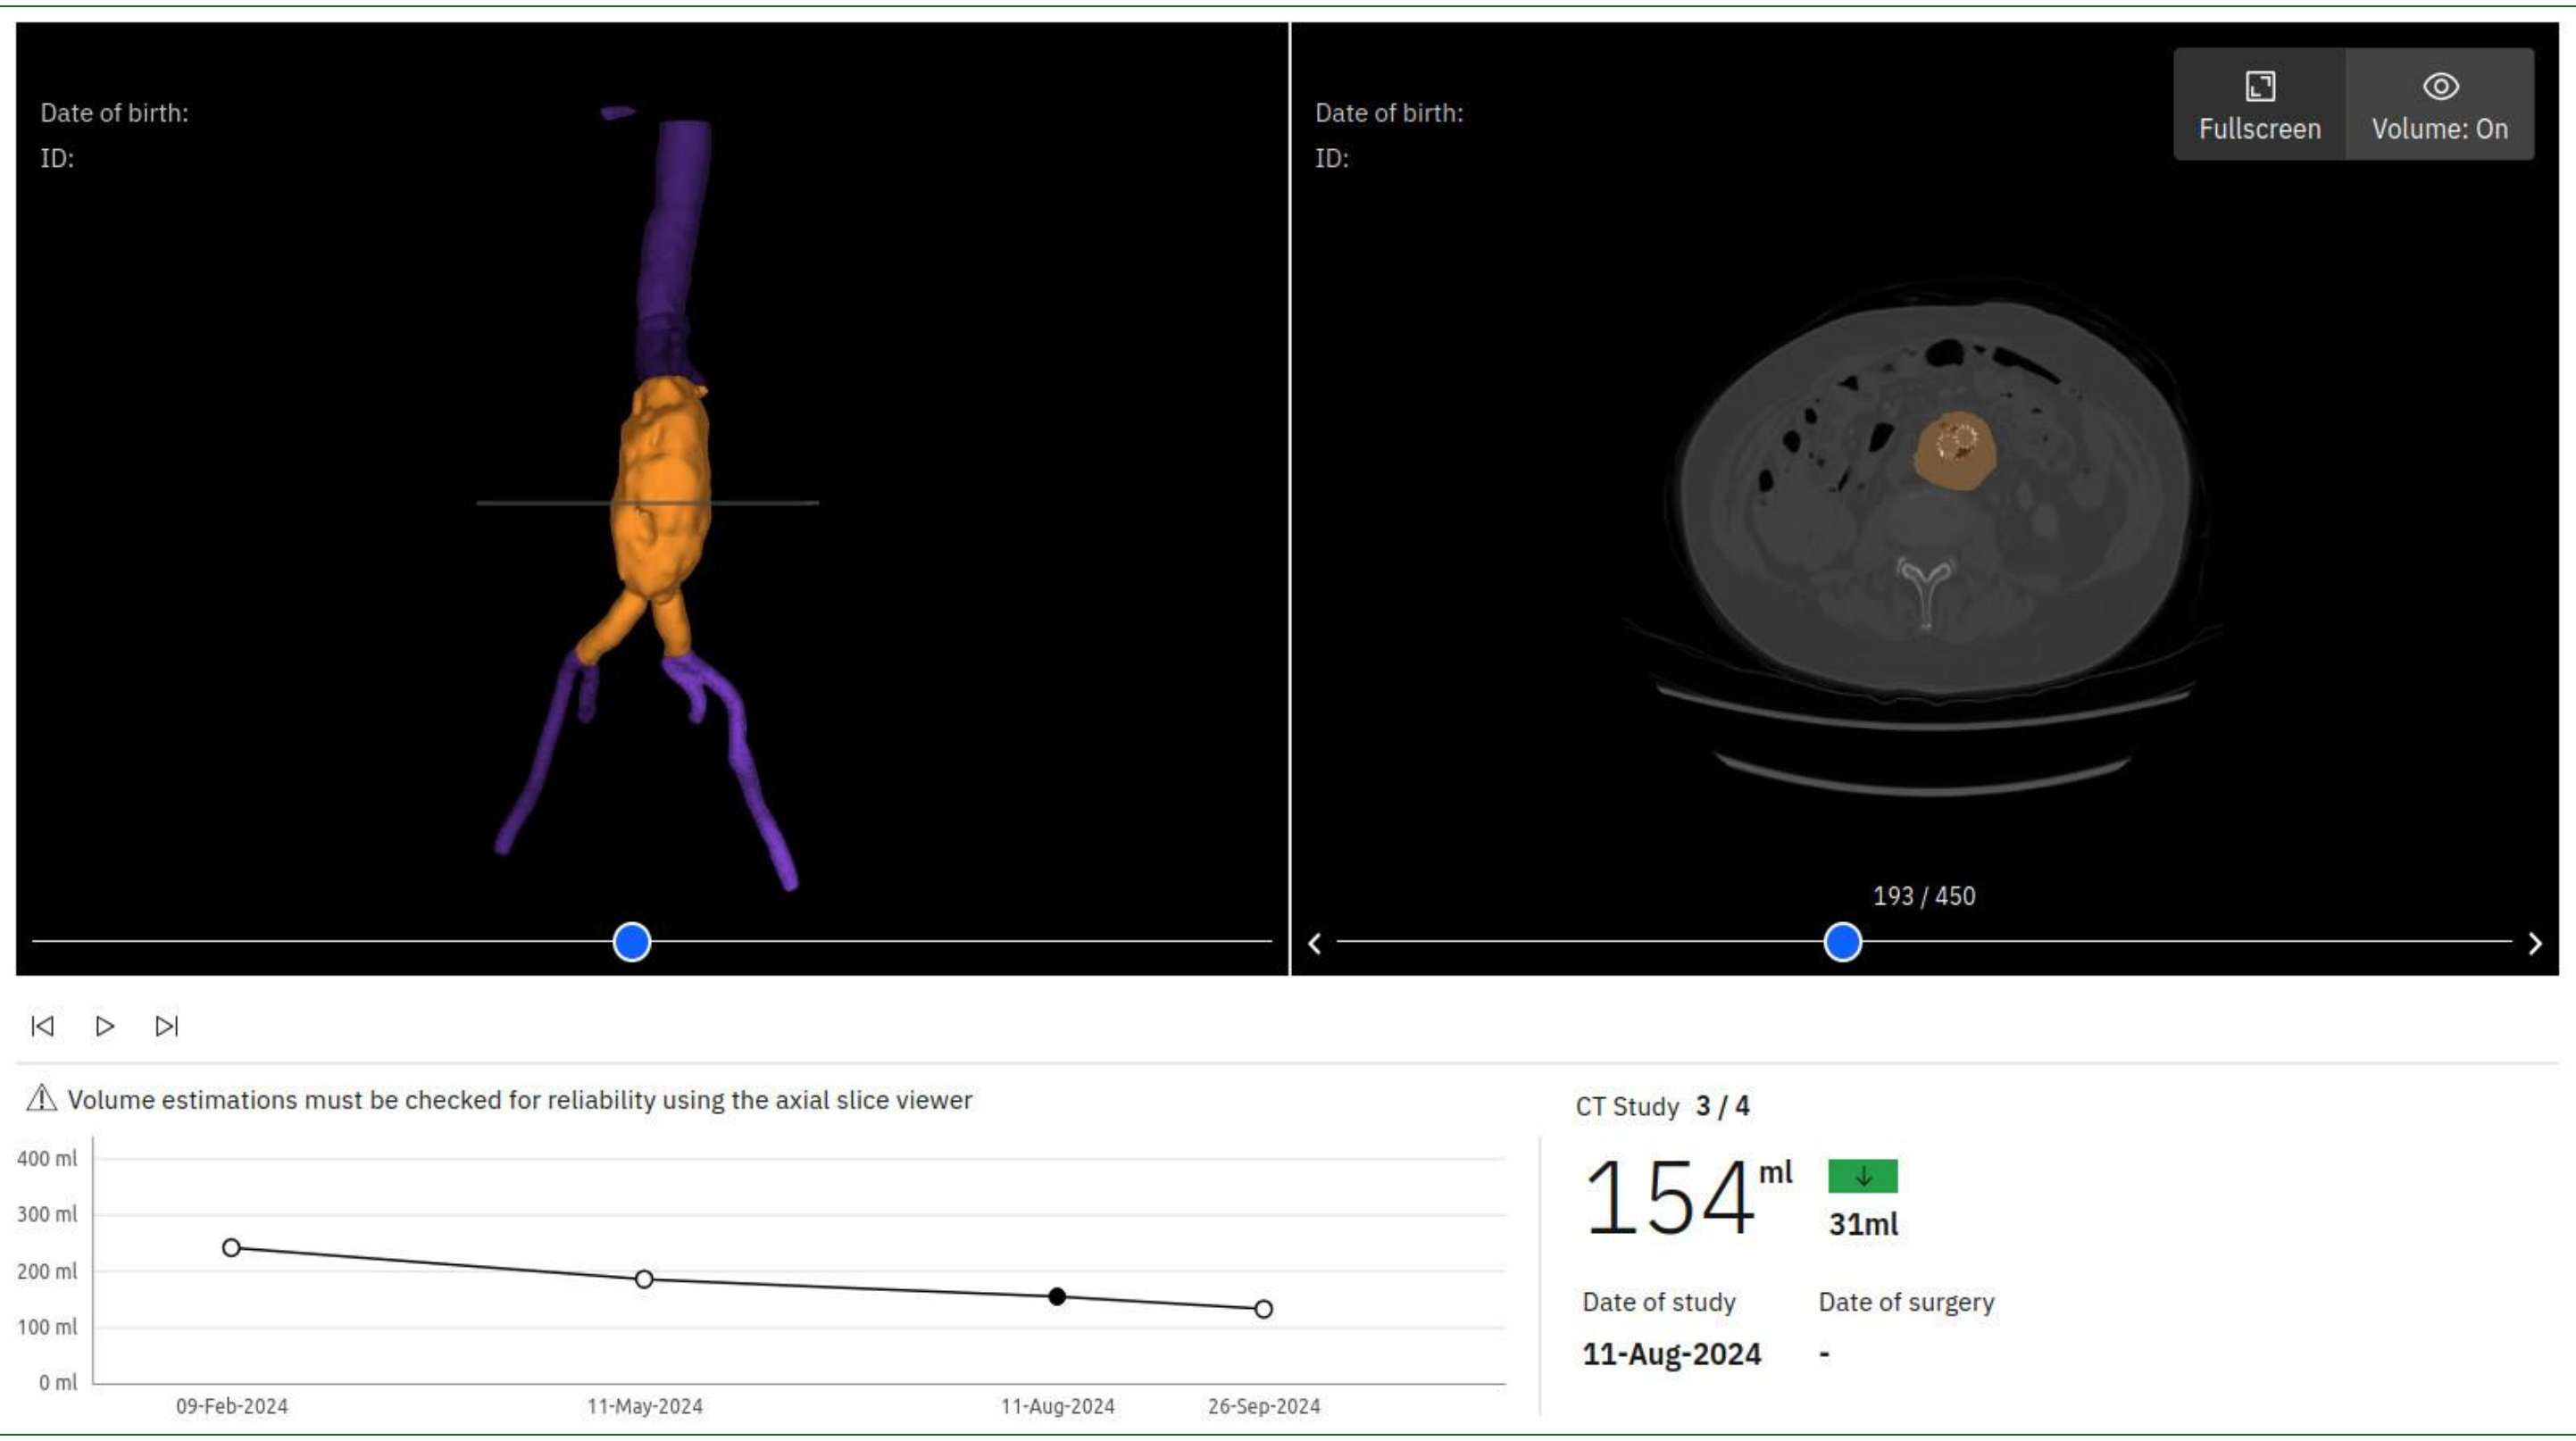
Automatic Volume Assessment (AVA) interface in Cydar Maps. The graph (bottom) shows the change in aortic volume over time, for the preoperative CT scan and three follow-up scans. The segmented volume can be viewed as a 3D rendering or as an overlay on the axial CT slices. The AVA volume (infra-real aorta plus common iliac arteries) is shown in orange.
